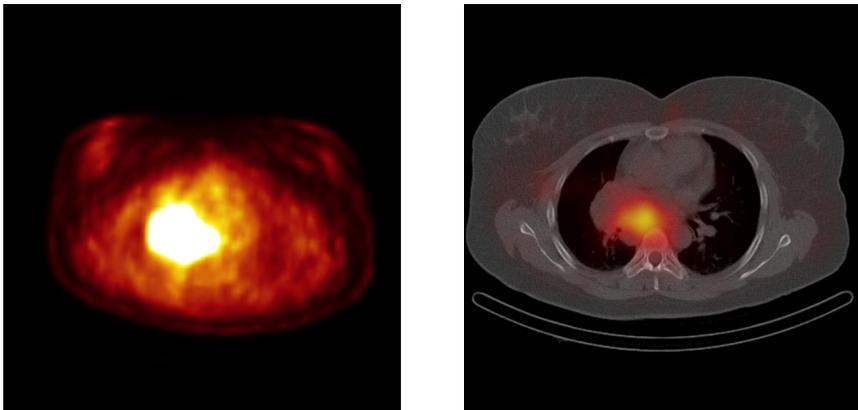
Combined imaging modality in a patient with a carcinoid tumor in the central area of the right lung. On the left: axial PET image showing intense tumor uptake of ^{18}F -FDG. In contrast, on the right, SPECT/CT shows uptake of ^{111}In -octreotide only in the mediastinal part of the tumor. The lack of tumor uptake of radiolabeled octreotide may be related to poor expression of membrane SSTRs whereas FDG accumulation is associated with overexpression of glucose transporters (GLUT 1 and 3) in the cell membrane. Most carcinoid tumors accumulate more octreotide than FDG due to its low growth rate and marked differentiation. However, there is variability and the individual tumor characterization may be helpful for the therapeutic choice. Abbreviations: PET, positron emission tomography; ^{18}F -FDG, ^{18}F -fluorodeoxyglucose; SPECT/CT, single photon emission computed tomography/computed tomography; SSTR, somatostatin receptor; GLUT, glucose transporter.
